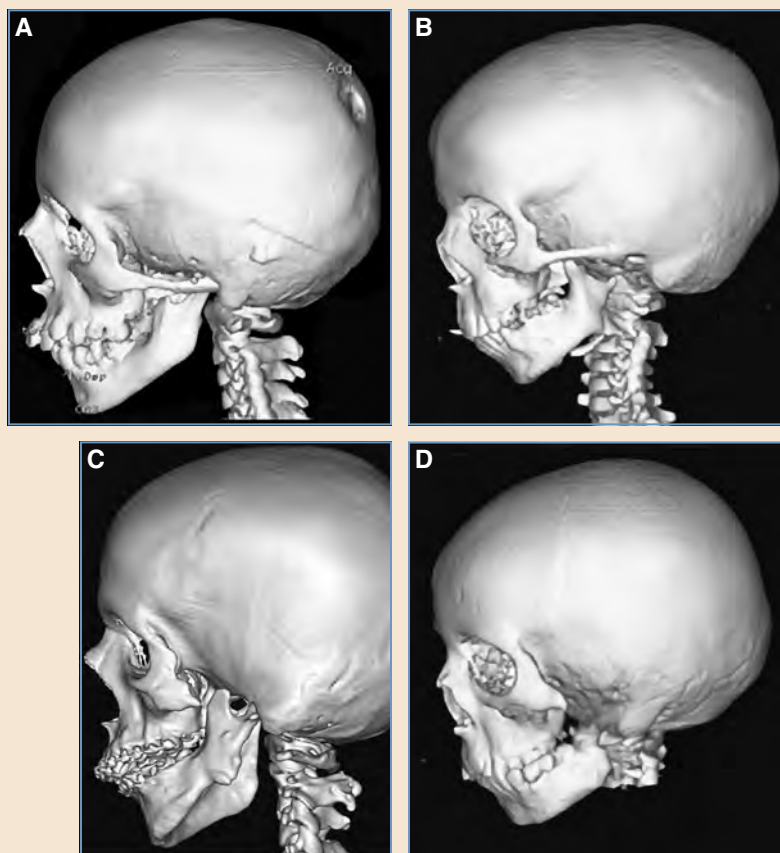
The variability in the skeletal deformity of CFM is shown in a series of CT scans. Common to all of the cases is a mandibular deformity with various components affected. A, Kaban-Pruzansky type I. B, Kaban-Pruzansky type IIA. C, Kaban-Pruzansky type IIB. D, Kaban-Pruzansky type III.
